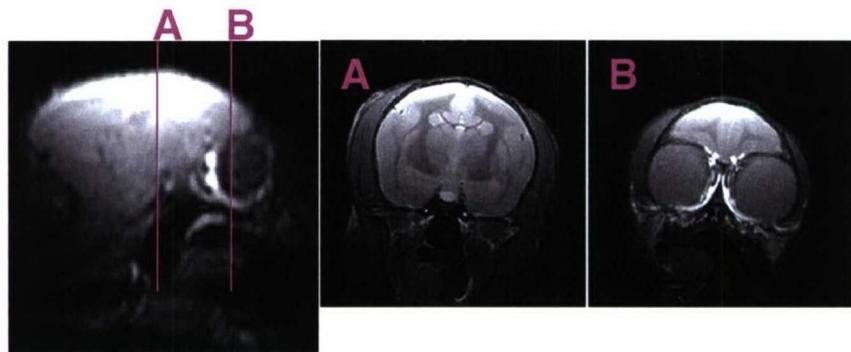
Electrode placement: The picture on the left shows a sagittal cross-section using magnetic resonance imaging (MRI). Line B lies anterior of line A. The two pictures on the right show cross-sections at the location of lines A and B. The electrodes were placed on the skull at these locations and 2 mm lateral of the midline.
